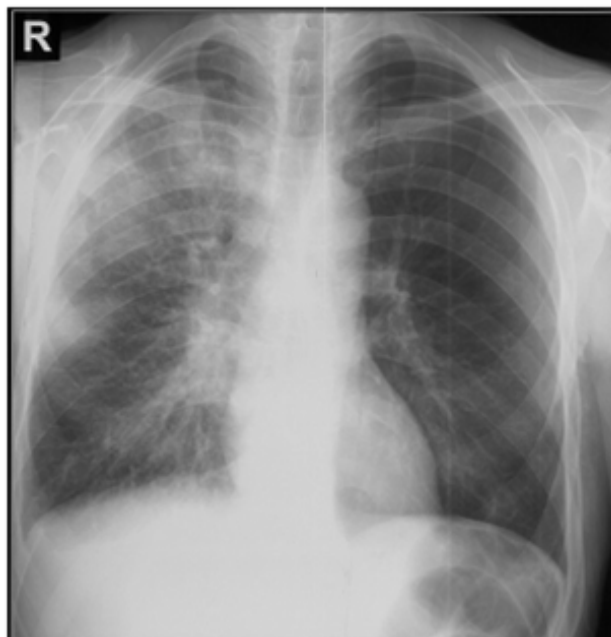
A postero-anterior chest radiography in a 53 years old male patient with acute pulmonary thromboembolism and right lung cancer reveals multiple heterogeneous opacities, with irregular borders and subcostal intensity in upper 2/3 of the right lung; enlargement of right hilum.
